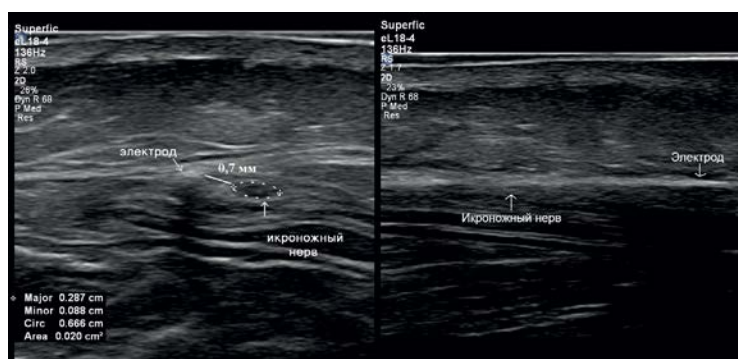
Ultrasound image of the implanted electrode.
